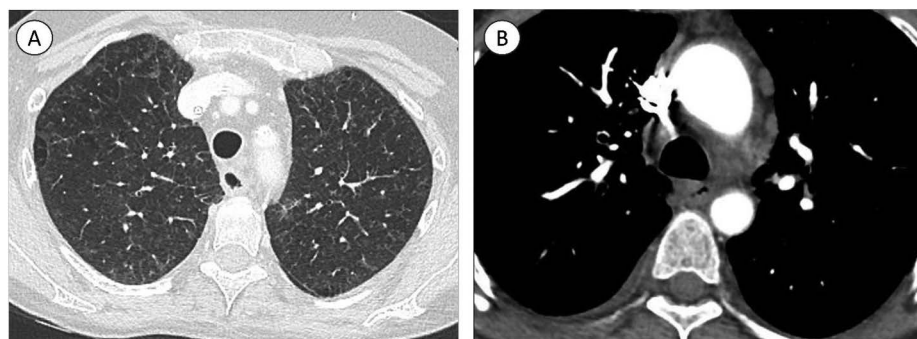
High-resolution CT scan of the chest in patients with PVOD. (A) Centrilobular ground-glass opacities and septal lines. (B) Mediastinal lymph node enlargement.
